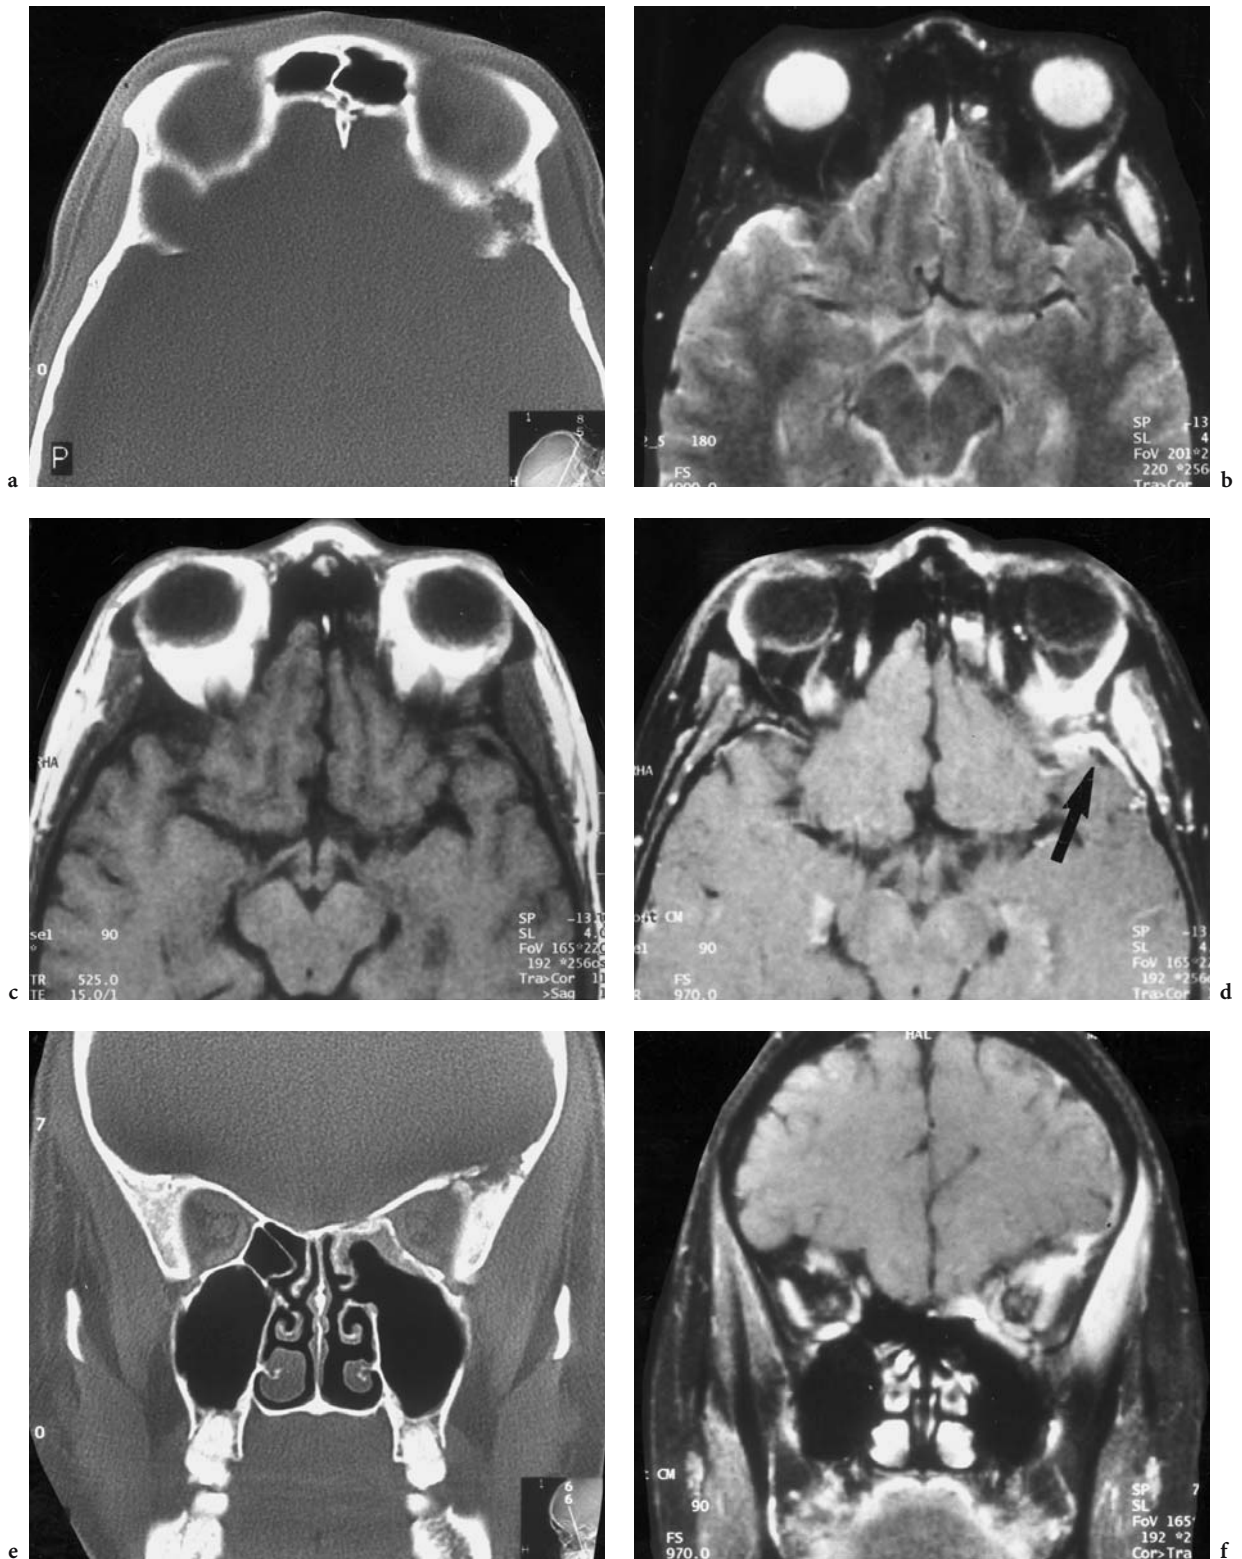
A 19-year-old woman with recurrent, generally painful proptosis, swollen upper lid, and chemosis of the left eye of still unknown etiology. Diagnosis: osteomyelitis of the left upper lateral orbital wall, involving the sphenoid and frontal bone and soft tissue of the upper orbit. a Axial CT (bone window) of the cranial orbital region with irregular destruction of the frontotemporal bone. b Corresponding T2-weighted MRI with hyperintense infiltration of the temporal muscle and the upper periorbital region of the left eye. c Corresponding T1-weighted native view. d Corresponding T1-weighted, contrast-enhanced (FS) view with bright enhancement of the involved tissue and the temporopolar dura (*arrow*). e Coronal CT (bone window) demonstrating apparent inflammatory infiltration. f Corresponding T1-weighted, contrast-enhanced (FS) MRI
